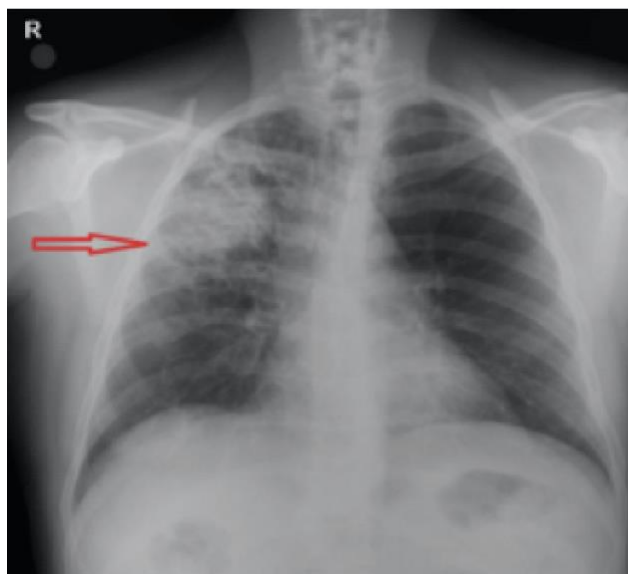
An area of infiltration in the upper zone of the right lung on PA chest X-Ray.
